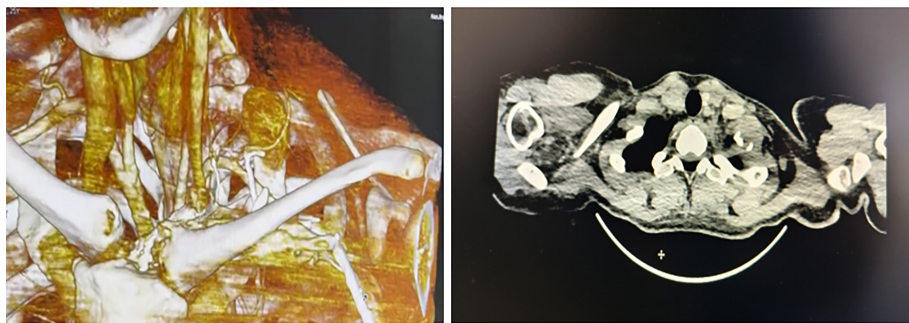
3D imaging and chest CT for high-position rib tumor. 3D, three-dimensional; CT, computed tomography.
